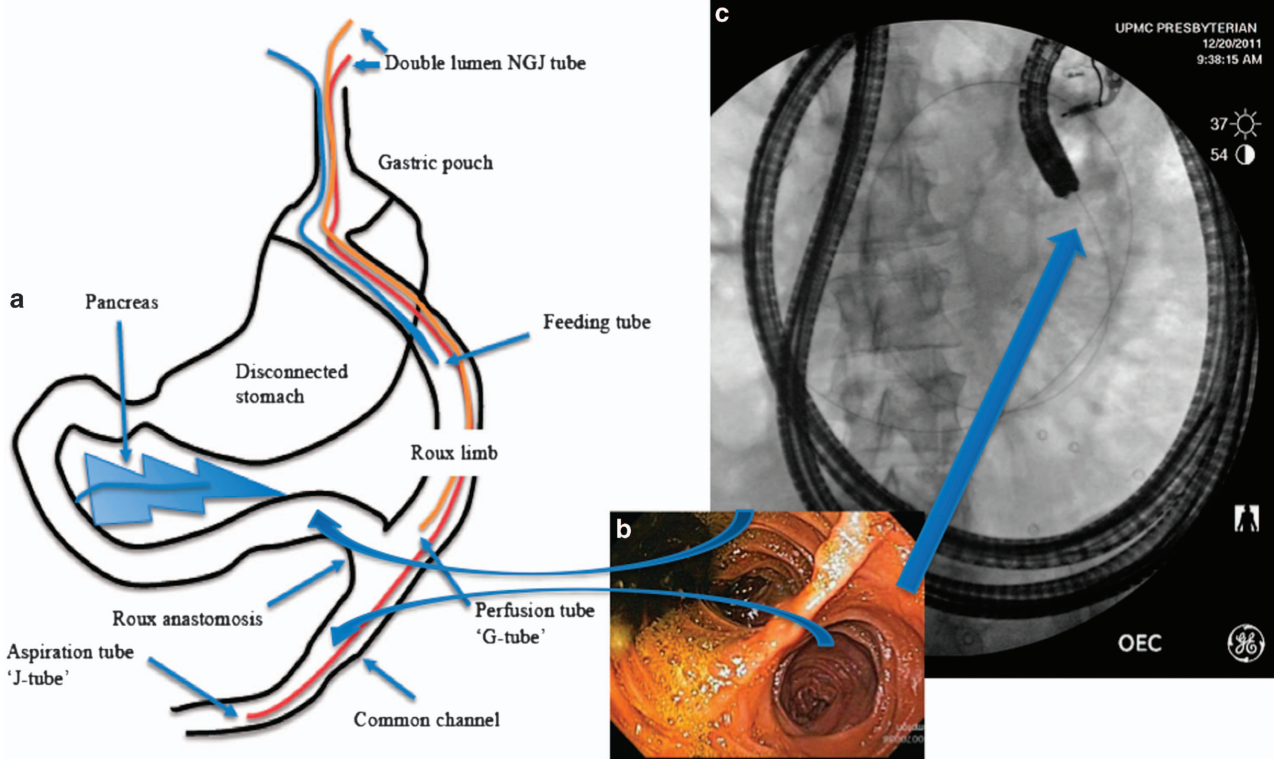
Positioning of the perfusion-aspiration tubes, and feeding tube for the measurement of pancreatic exocrine secretion (a) left panel. This was achieved by enteroscopy (b) middle photograph showing the Roux anastomosis, and fluoroscopy (c) radiograph upper right image and guide wire deployment. Blue arrows connect shared features of the three images.
